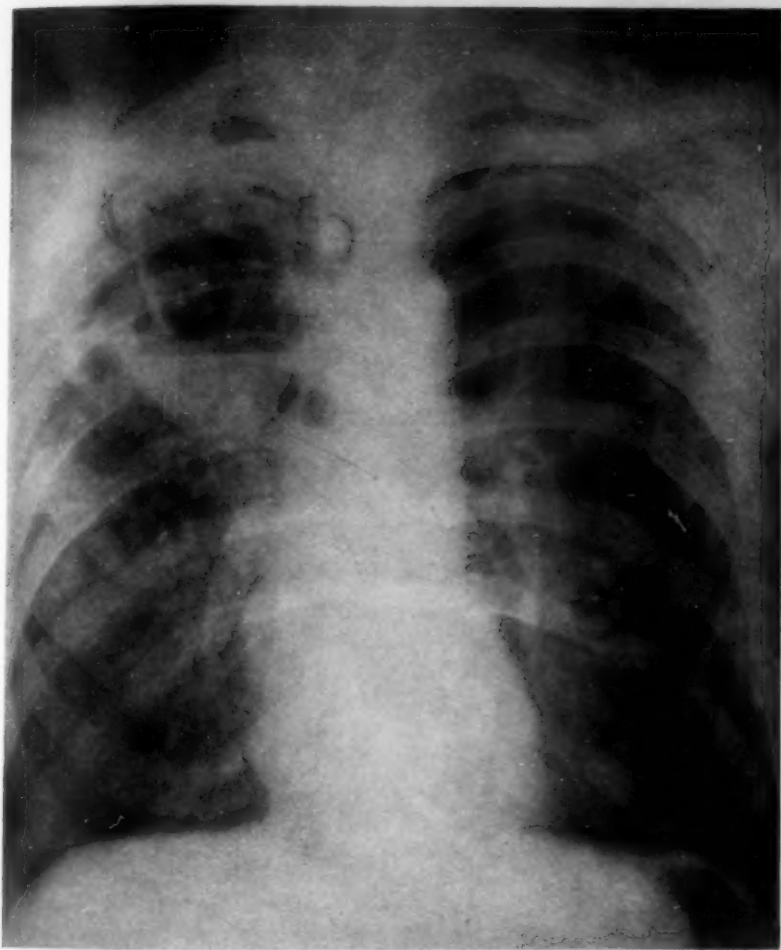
Chest x-ray July 18, 1940. Multiple cystic areas in upper right lung field. Two fluid levels are visible. Bullous emphysema of upper left lung field.
